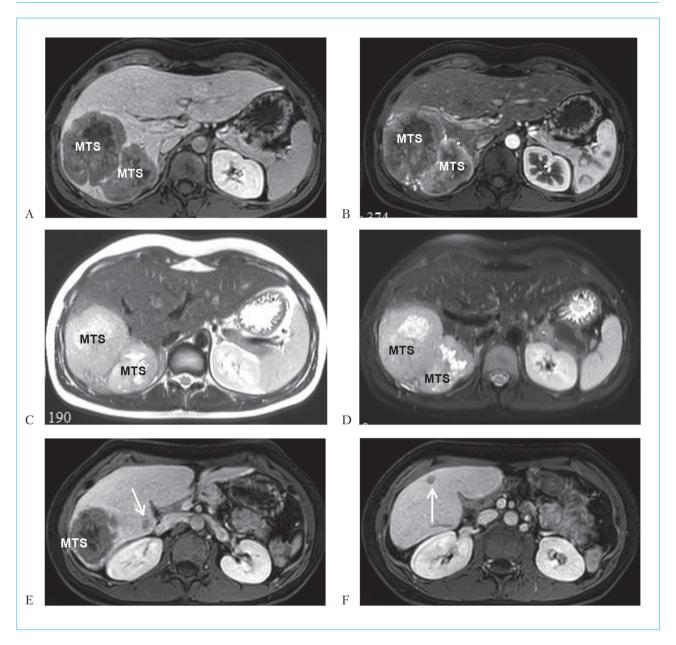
MRI of liver metastases, two large foci in the VI–VII liver segments: A-T1-WI; B-T1-WI with contrast enhancement; C-T2-WI; D-T2-WI in fat suppression mode; E- large focus of VII and small focus of VIII liver segments, T1-WI; F- small focus of V liver segment, T1-WI
